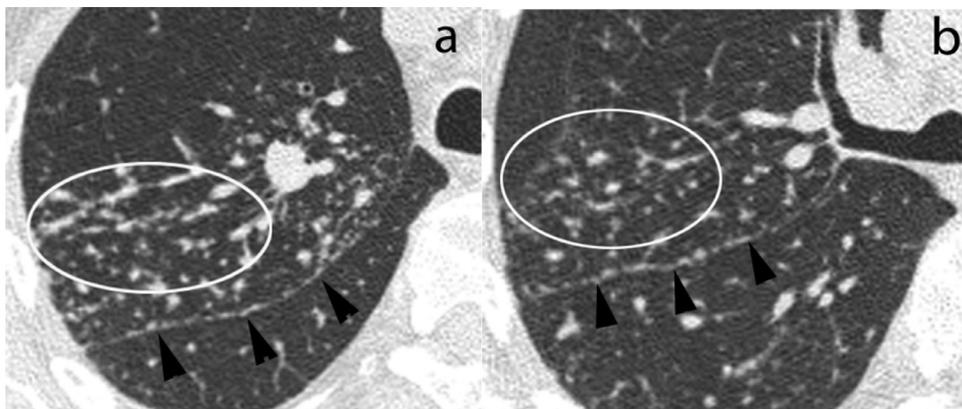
(a, b) CT showing nodules in the perilymphatic distribution along the bronchovascular bundles (ovals) and fissural pleura (arrowheads). CT, computed tomography.
